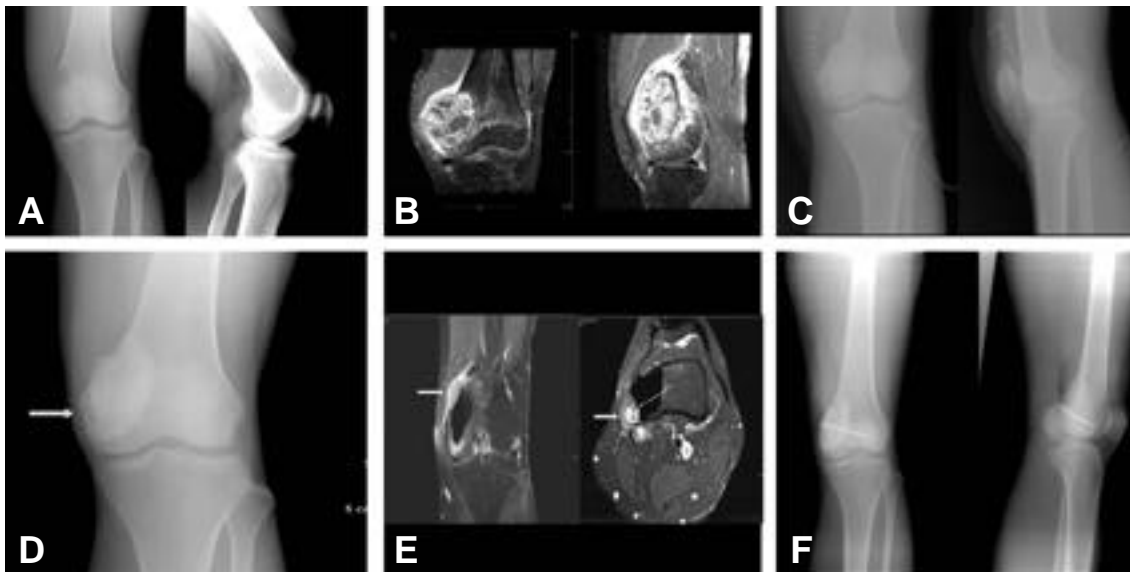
Twenty-three years old female patient complained knee pain for several months. (A) Initial plain radiographs (B) Initial MRI of distal femur (C) Postoperative plain radiographs after curettage & cementation (D) Follow-up radiographs show recurrence (arrow). (E) Follow-up MRI show recurrence just around window area (arrow). (F) 2nd curettage & cementation for recurrence
